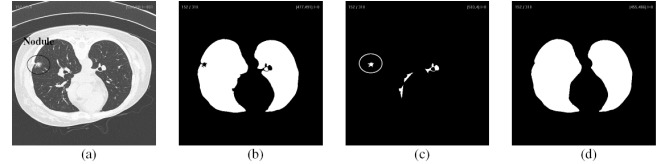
Lung segmentation based on a fuzzy thresholding method; processing goes from left to right. (a) Original CT lung image; (b) Lung mask extraction from fuzzy thresholding; (c) Segmented concave regions (an attached nodule and other attached tissues) based on critical points; (d) Final segmented lung mask formed by adding the (b) and (c) to produce the final lung mask.
